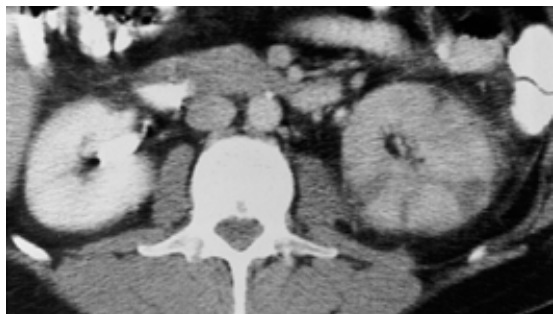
27. Acute pyelonephritis of left kidney. Contrast-enhanced computed tomography scan. Note perinephric fascial thickening due to edema and wedge-shaped defects in the parenchyma that extend from the collecting system to the capsule. The nephrogram is delayed overall compared with the right kidney.
